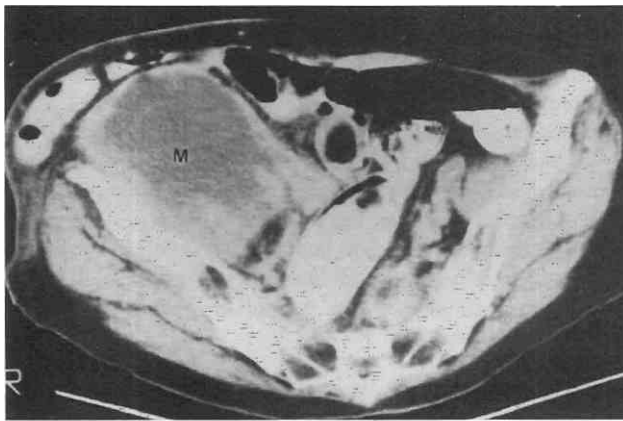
Malignant mass involving the iliopsoas muscles. Nondynamically enhanced CT scan shows a large, mildly heterogeneous mass (M) representing a colon cancer metastasis and infiltrating the right iliopsoas muscle. This mass would be difficult to distinguish from an abscess or a hematoma.
